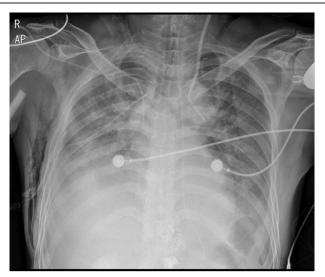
The left internal jugular catheter is not across the midline with catheter kinking shown on this chest x-ray.
